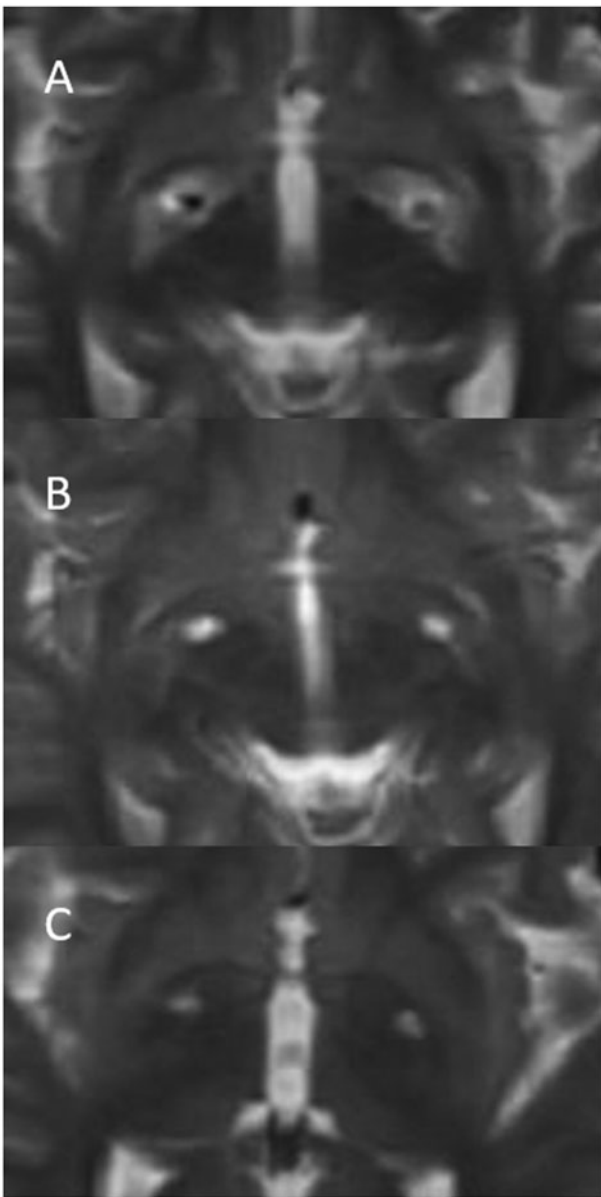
A: MRI scan performed eight days after DBS surgery, with electrodes still in place within the GPi; B and C: MRI scans performed at 3 and 6 months after surgery, respectively.
